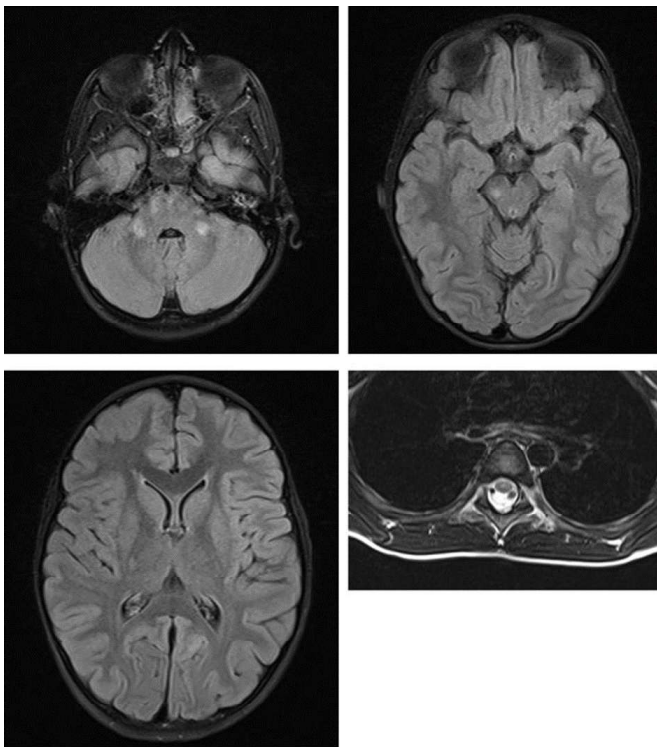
Cranial and thoracic spinal MRI subsequently demonstrated hyperintense T2/FLAIR lesions in the right cerebral peduncle and cerebellum, with thoracic spine demonstrating discrete intramedullary foci of hyperintensity spanning T9 to T12 (in the central cord, anterior funiculi, and posterior funiculi), notable for the absence of gadolinium enhancement.
